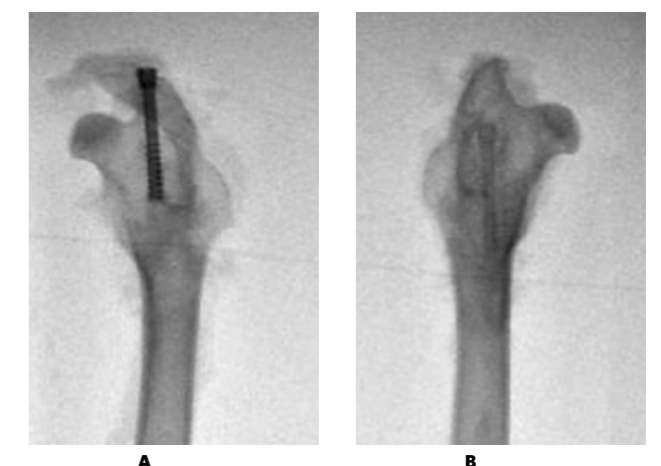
Radiographs of the femoral bone after 6 months: on the left — a titanium screw; on the right — BDI, its contours are blurred, the borders are difficult to determine, the intensity of the shadow is significantly reduced
